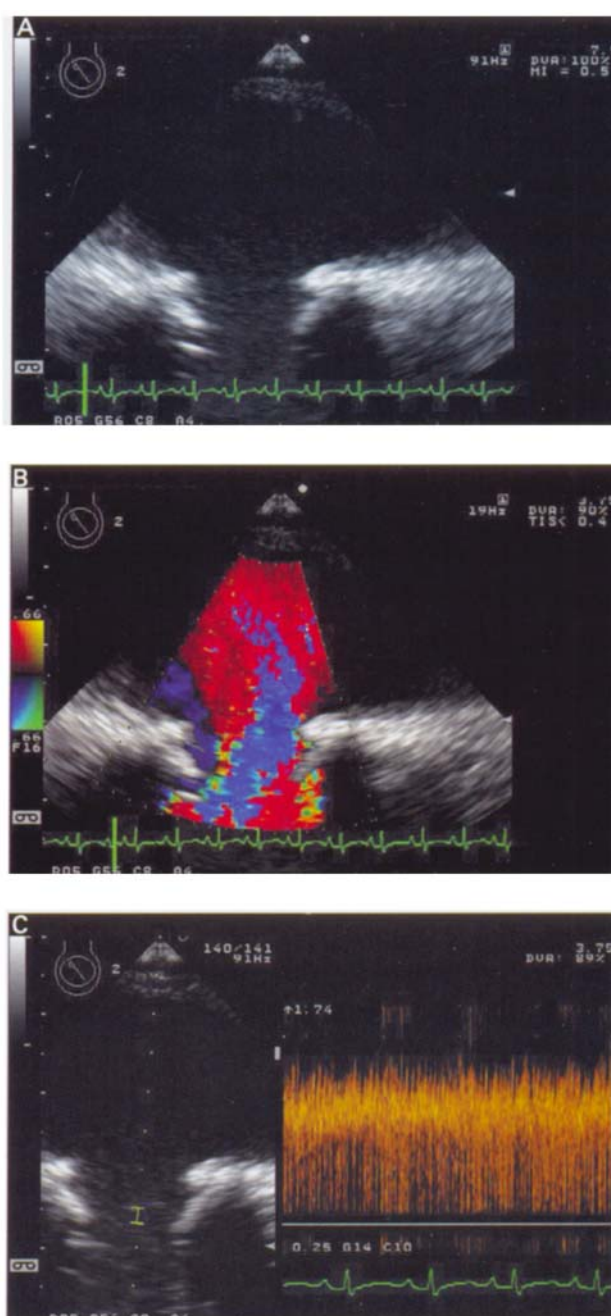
The anastomosis of the outflow cannula of a non-pulsatile left ventricular assist device (LVAD) to the descending aorta is imaged in (A) the long-axis view of the descending aorta, (B) with colour flow Doppler, and (C) with pulsed wave Doppler, showing continuous flow without pulsatility.
